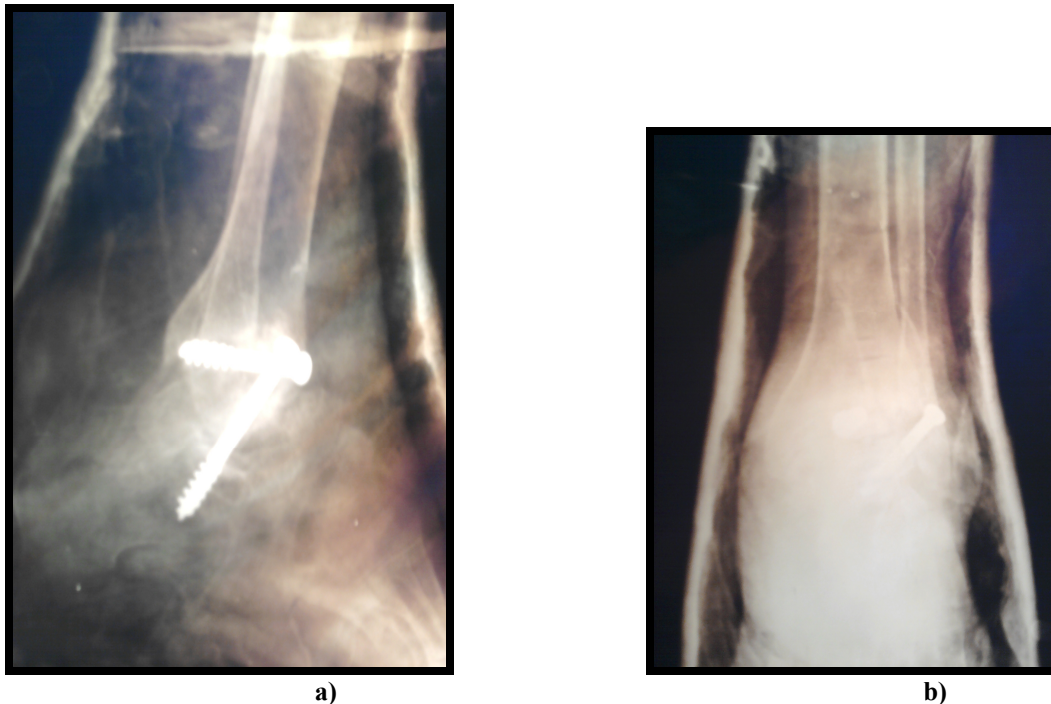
Post operative lateral (a) and anteroposterior (b) X-rays of arthrodesed right ankle joint using two cancellous screws.
